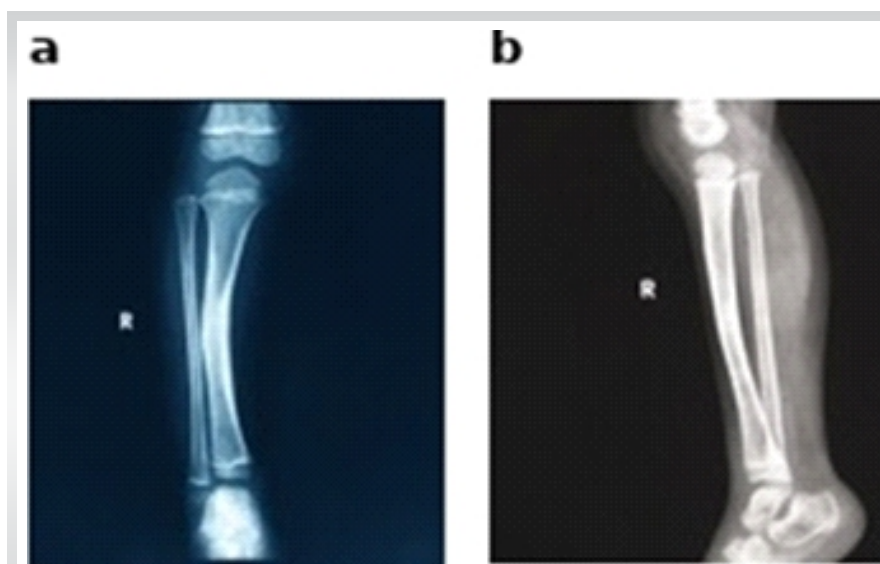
Anteroposterior and lateral radiographs of the right tibia and fibula. Anteroposterior (a) and lateral (b) radiographs of the right tibia and fibula obtained in 2021, at approximately 4 years of age, demonstrating anterolateral bowing of the tibia at the mid-diaphysis without fracture. The characteristic anterior and lateral curvature is present with a patent medullary canal, without hourglass tapering, cystic change, or cortical breach, corresponding to Paley type 1.
